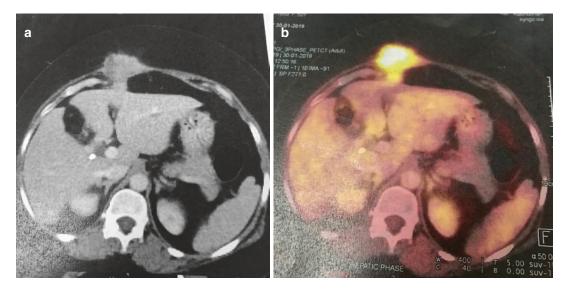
Isolated port site metastasis on (a) CT and (b) PET
